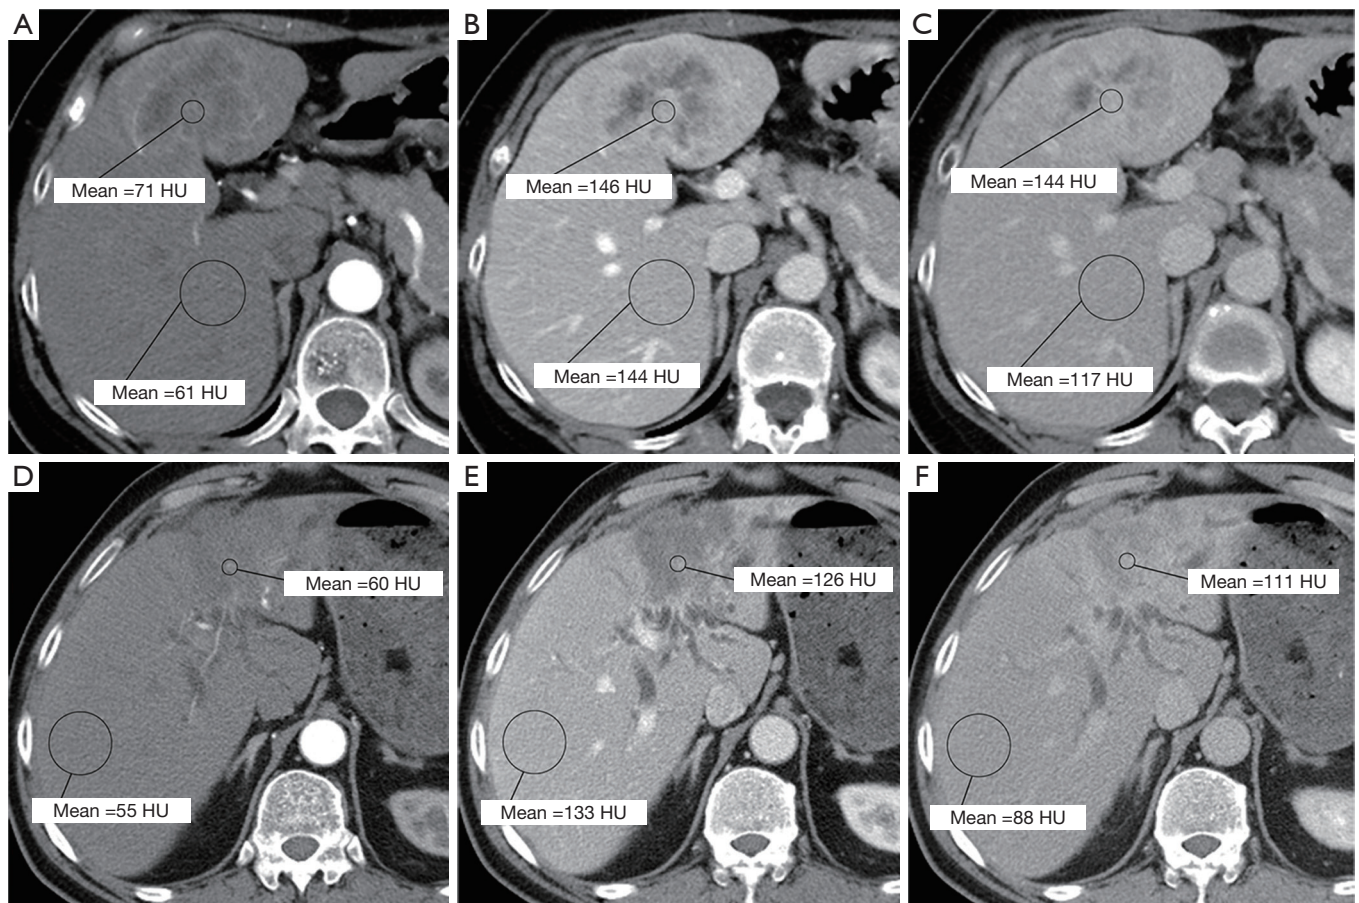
Axial CT images show a mass-forming (MF) type intrahepatic cholangiocarcinoma (ICC) in the arterial phase (A), portal venous phase (B) and equilibrium phase (C) in an 85-year-old woman. Axial CT images show a non-MF type ICC in the arterial phase (D), portal venous phase (E) and equilibrium phase (F) in an 83-year-old man. A region of interest (ROI) is placed in solid part of the lesion with remarkable enhancement avoiding visible vessels, necrosis or calcifications in each phase. A second ROI is placed in non-tumorous liver parenchyma in the same slice as large as possible avoiding visible vessels in each phase.
